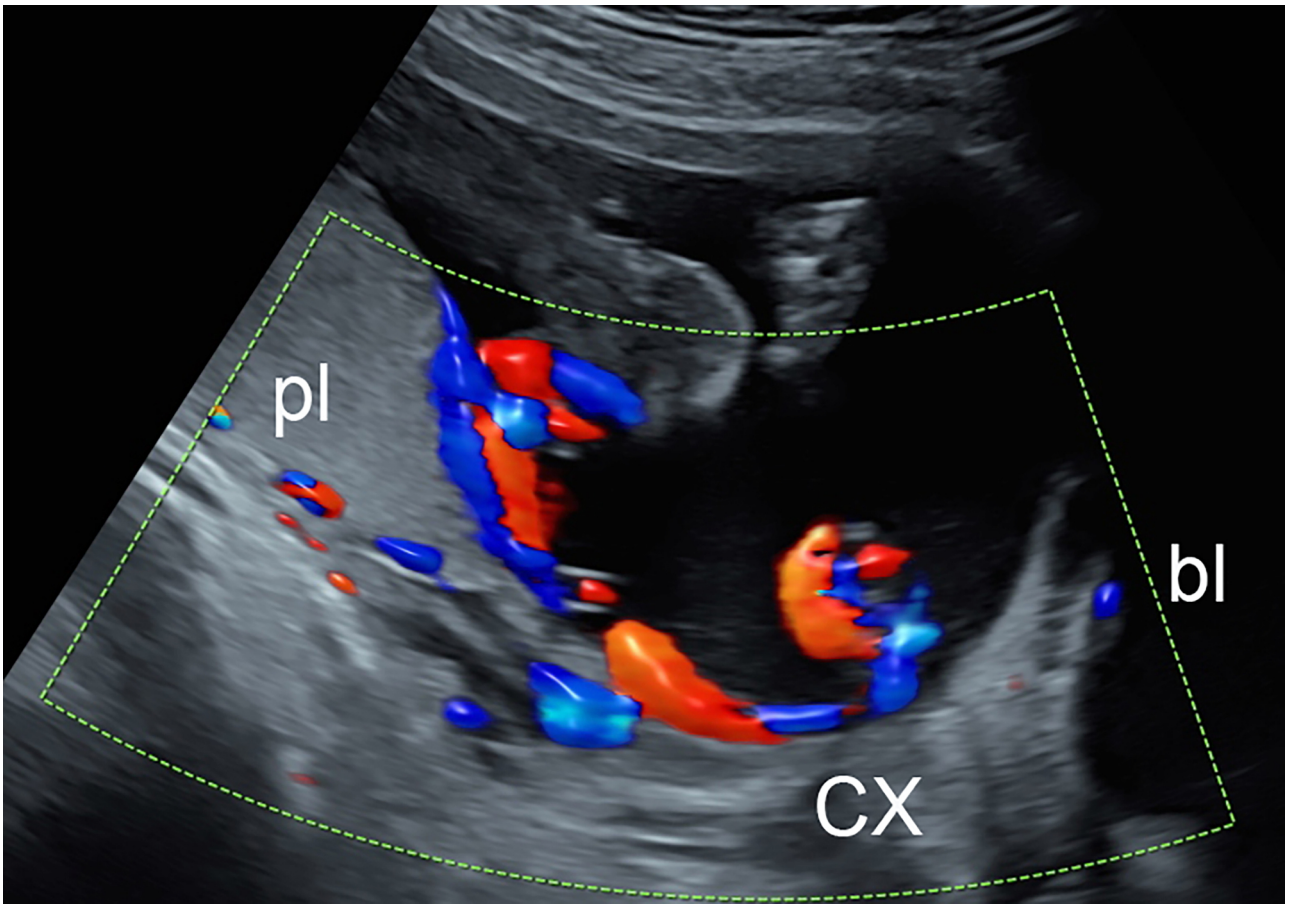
(a) Grayscale transvaginal ultrasound of the same patient in Figure 2, showing the cord inserting into the membranes over the cervix (cx), from where unprotected vessels run into the posterior placenta (pl) confirming vasa previa. (b) TVS/CDI of same patient.
